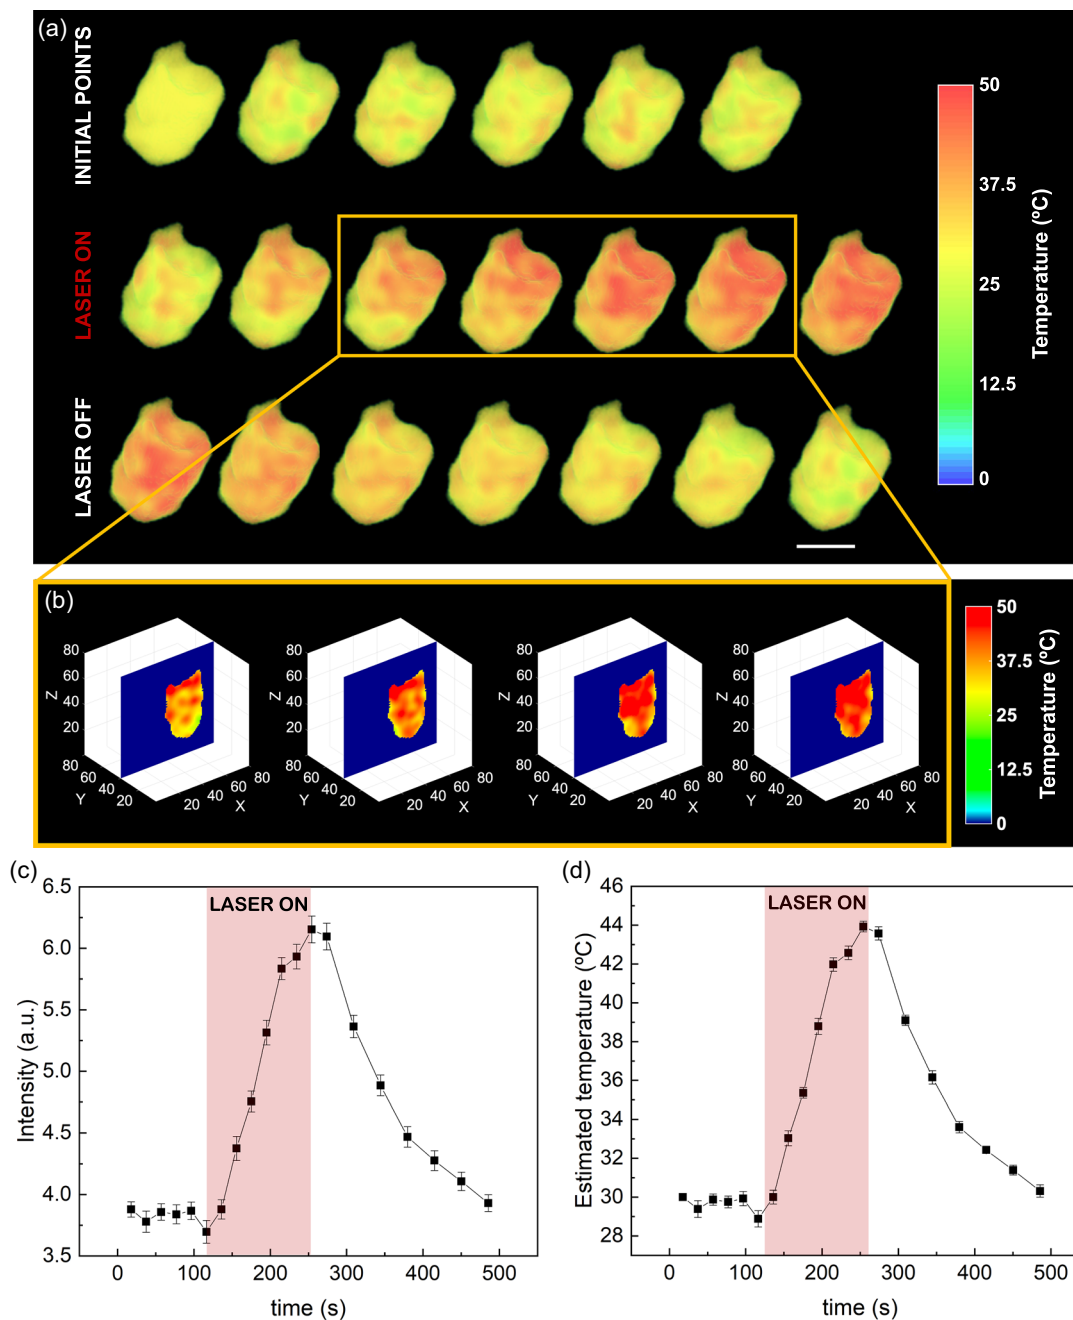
a) 3D temperature maps obtained with a cell sample ($250 \mu\text{g mL}^{-1}$ incubation concentration of Fe_3Se_4 NPs) before, under, and after NIR irradiation for 120 s at 1.5 W cm^{-2} (scale bar = 3 mm); b) 2D projection of a slice of the 3D temperature map in the xz plane during laser irradiation; c) variation of the average intensity of the ROI during the laser experiment; and d) variation of the average temperature estimated from the intensity images during the laser experiment. The associated MRI intensity images are shown in Figure S22, Supporting Information. Please see the Supporting Information Videos with the temporal evolution of the MR images and temperature maps.
